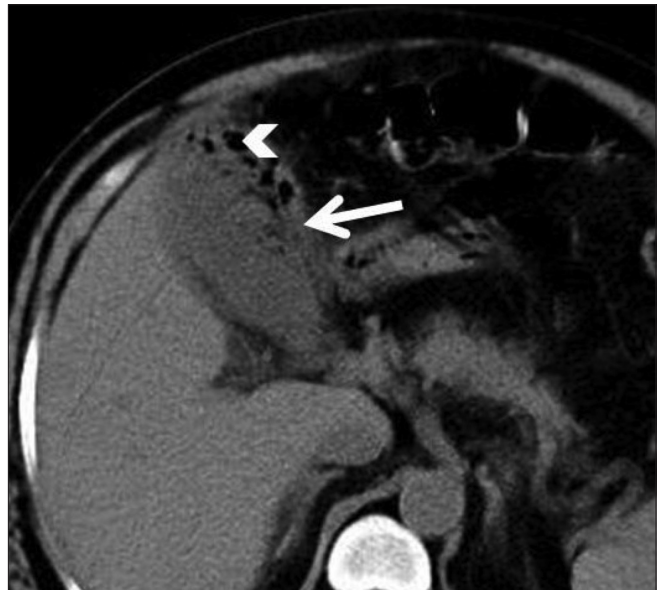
Axial CT scan shows gall bladder wall thickening (arrow), with intramural air (arrowhead)
